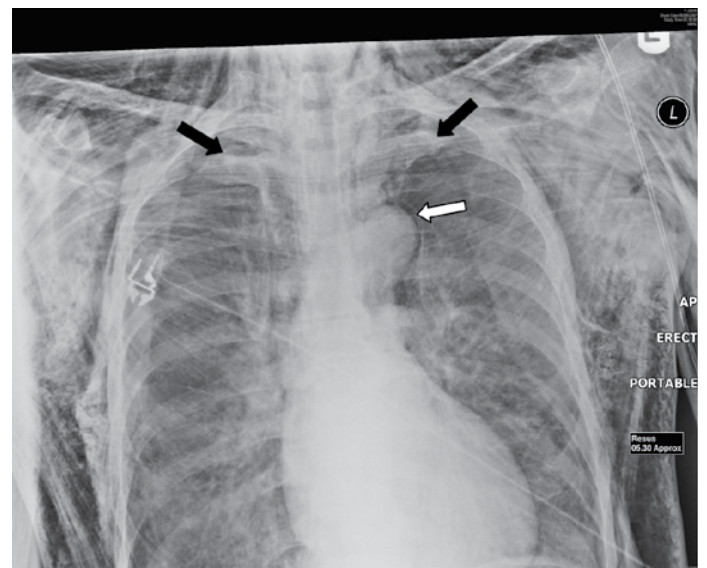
Chest X-ray of a different patient, with severe surgical emphysema, throughout the X-ray. Bilateral pneumothoraces are seen (black arrows), with air in the mediastinum and around the aortic knuckle (white arrow). Radiolucent striations are seen outlining the pectoralis major when there is surgical emphysema in the anterior chest wall (Ginkgo leaf sign)
